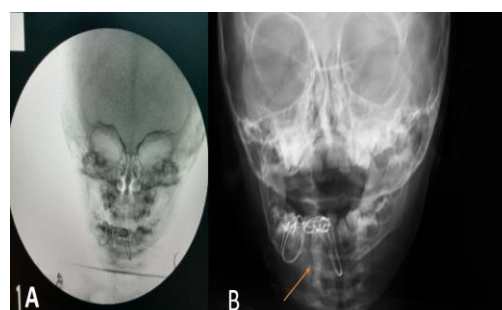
A, B. Adequate Bone Reduction Confirmed by Intraoperative C-arm Radiography and Postoperative PA-mandibular View
